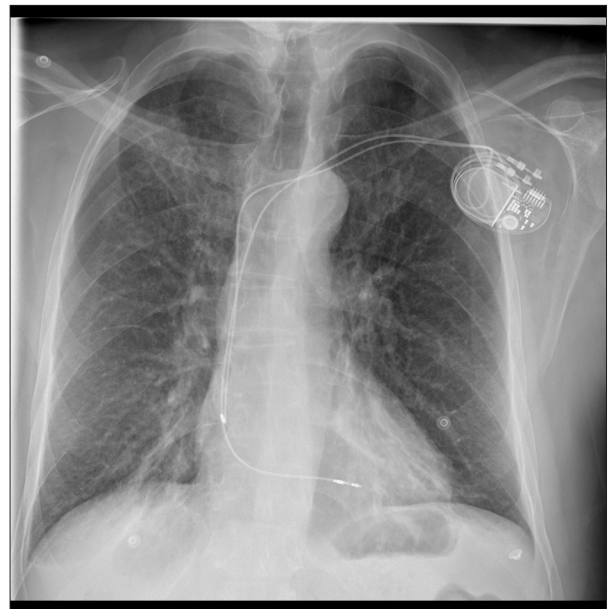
Chest X-ray following dual-chamber pacemaker insertion.
